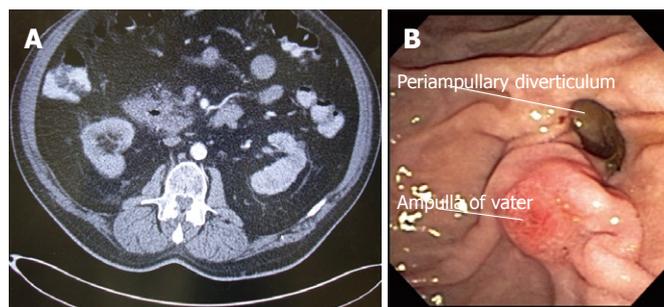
A duodenal diverticulum with ampulla. A: Computed tomography scan of abdomen with gas collection in pancreatic head representing periampullary diverticulum penetrating in pancreatic tissue; B: Periampullary diverticulum
